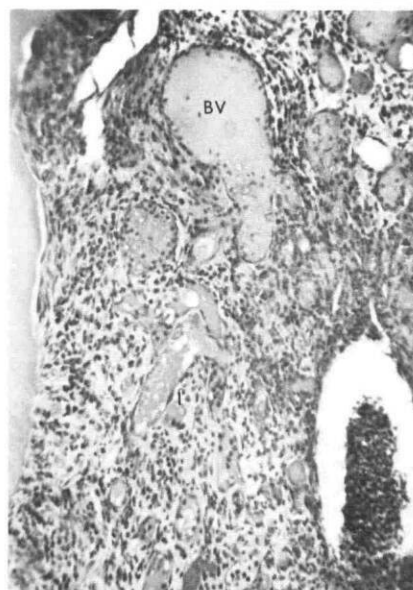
A magnification of the periapical area of a lower permanent molar 24 months after treatment with the full concentration showing a heavy inflammatory infiltrate (I) and enlarged blood vessels (BV) (5x).
